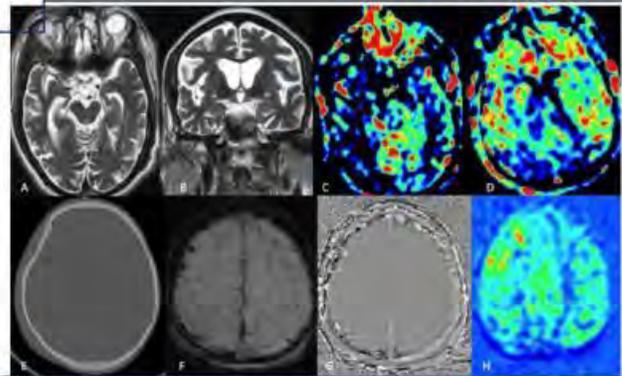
1st row shows images of a case of posterior cortical variant of Alzheimer's disease. Axial (A), coronal (B) T2W images shows predominant atrophy of bilateral medial temporal lobes & hippocampi. PCASL images (C,D) shows hypoperfusion of bilateral posterior parietal regions and bilateral temporal lobes. 2nd row shows images of a case of Head Injury. Bone algorithm CT image (E) shows comminuted fracture in frontal bone. Susceptibility Weighted image (F) and phase map (G) shows hemorrhagic contusions in right frontal lobe. PCASL Image (H) shows hyper perfusion of this region suggestive of trauma induced perfusion changes
